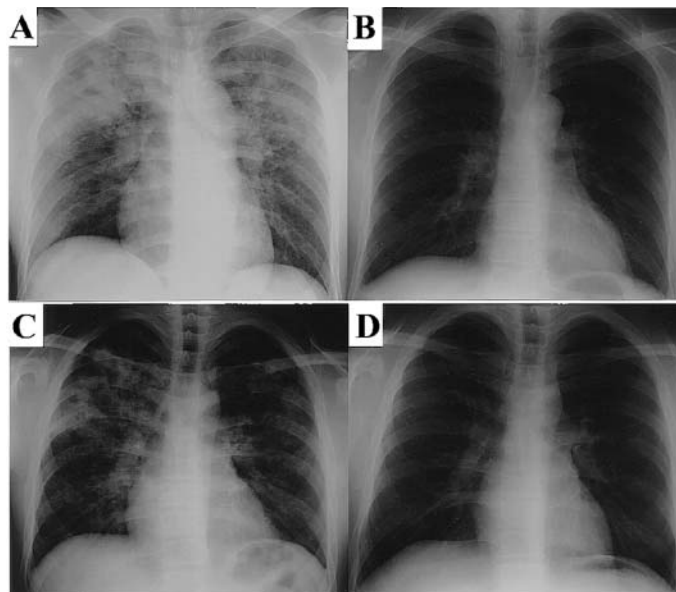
Chest radiographs of spray-induced patients.
